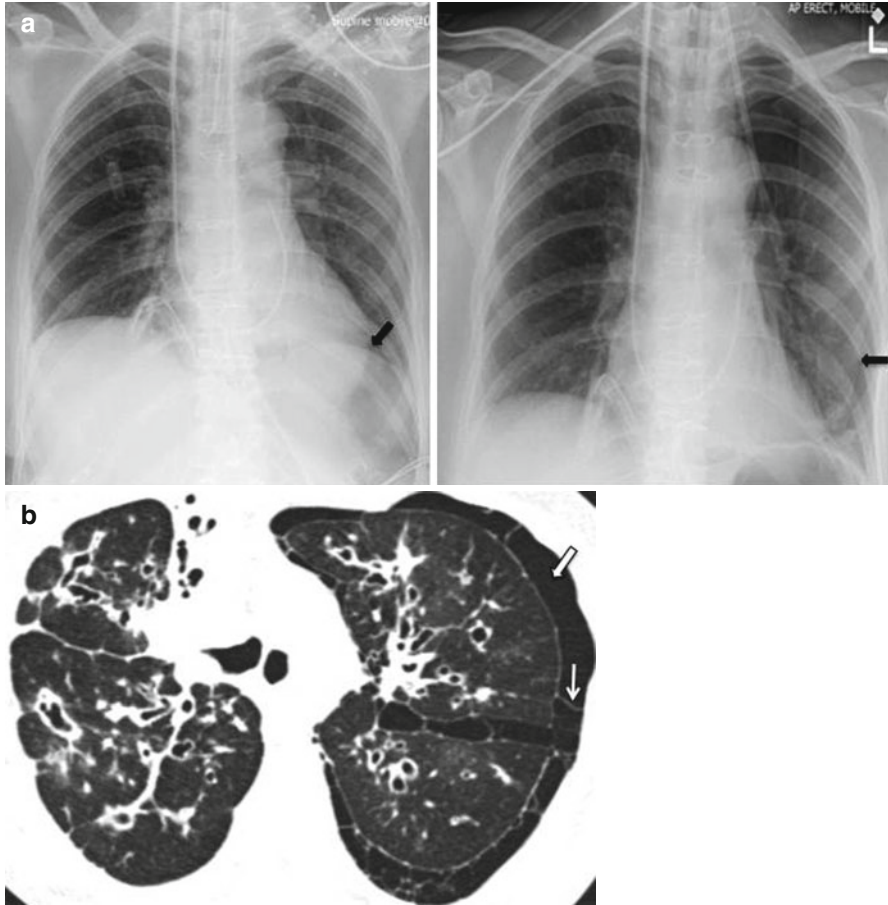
(a) Supine pneumothorax: Serial chest radiographs on a 65 year-old ventilated female. *Left panel* shows abnormal lucency over the left hemidiaphragm with a resultant “crisp” outline (*block arrow*), and deepening of the costophrenic angle due to a supine pneumothorax. This was missed but subsequently picked up following a repeat erect film (*right*) where the basal pneumothorax is obvious. (b) Axial CT in a 20 year-old male demonstrating extensive bilateral cystic and varicose bronchiectasis due to cystic fibrosis with a complex left pneumothorax (*block arrow*) containing internal septations (*thin arrow*). Even small pneumothoraces may require drainage when there is such poor respiratory reserve and is generally safer when performed under CT guidance
